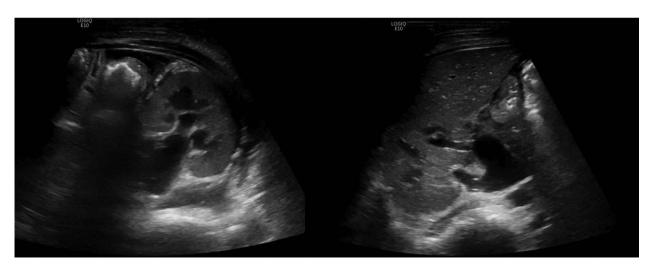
Renal ultrasound on POD #2 demonstrating bilateral pelvicalyceal dilatation.
